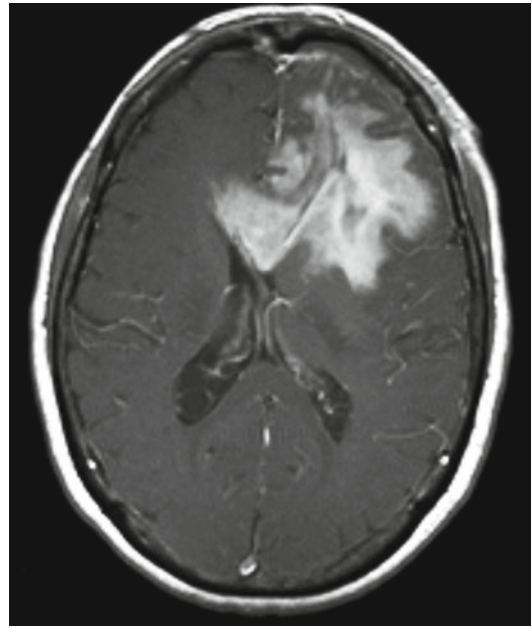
T1-weighted MRI scan of the brain with gadolinium, showing a diffusely enhancing area in the left frontal lobe (Reproduced with permission from Singh et al. [5])
